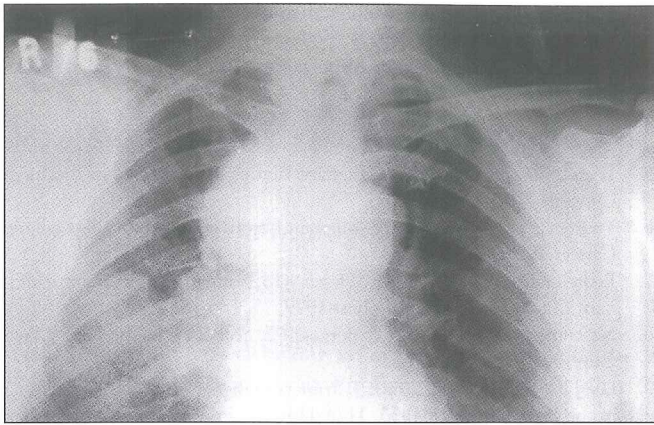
Posteroanterior chest x-ray showed a mass lesion in the mid-right lung zone and also widening of upper right side of mediastinum
